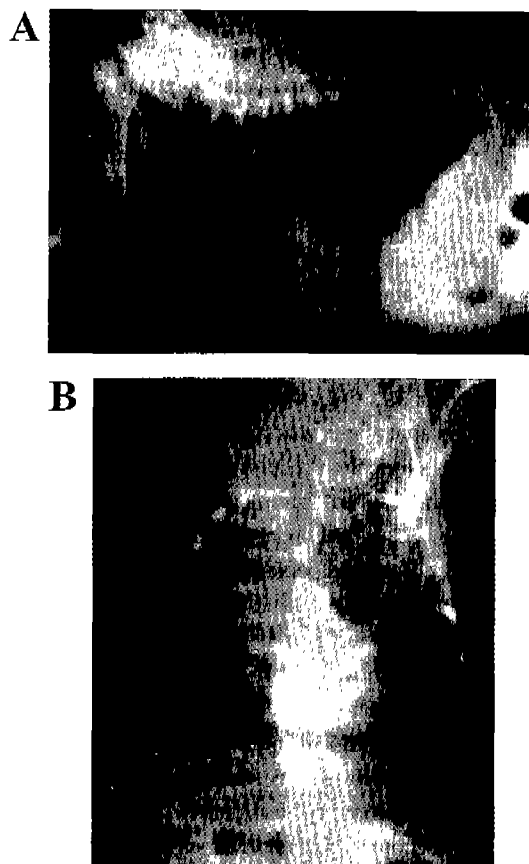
On thoracic radiography, esophagus was dilated generally from cervical to caudal esophagus except at heartbase and trachea was displaced ventrally in lateral view (A) and to right-side in ventro-dorsal view (B).
